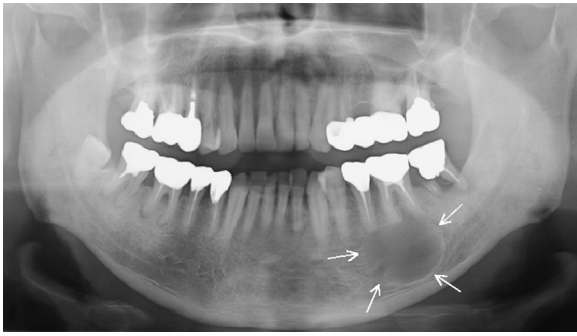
Panoramic radiograph showing a well-defined unilocular radiolucent lesion (arrow) in the left posterior mandible.
